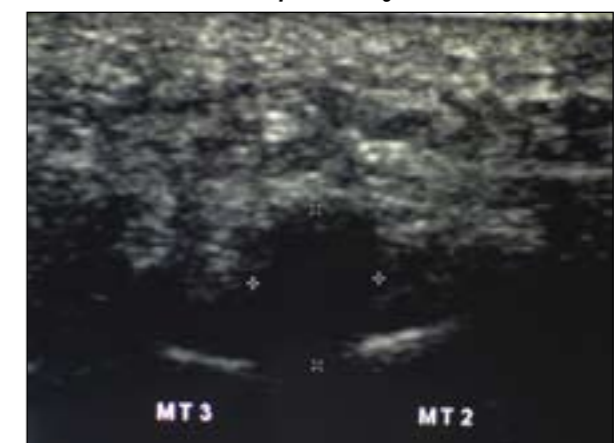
Ultrasound scan of a forefoot showing a hypochoic Morton's neuroma in the second to third interspace. The plantar surface of the foot is at the top of the image.
